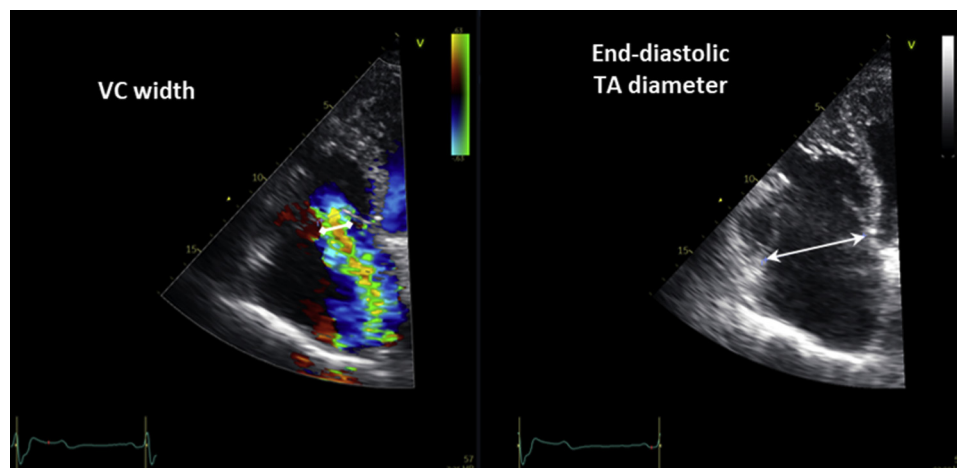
VC/TA ratio to identify disproportionate and proportionate STR. Proportionate and disproportionate STR may be defined on the basis of the ratio between two linear standard echocardiographic measurements: the numerator represents the grade of STR (VC width), while the denominator reflects right heart remodeling (tricuspid annular diameter). This approach makes it possible to mathematically relate STR grade to the dilatation of the TA.
